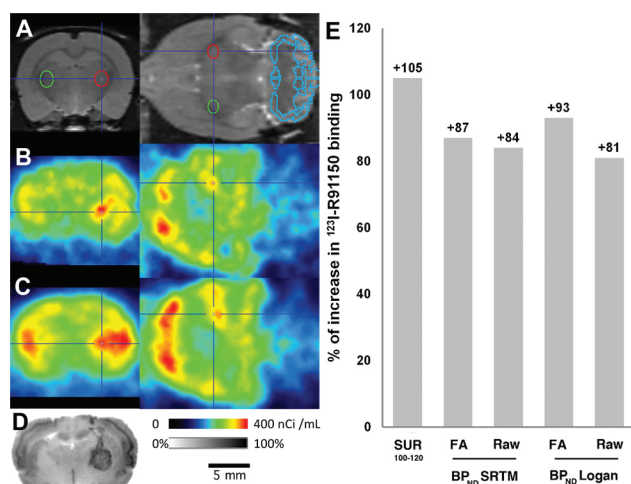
Adenoviral overexpression of 5-HT_{2A} receptors. MRI template with cerebellum and adenovirus injection-site regions of interest (ROI) (Ad5-HT_{2A}R = red ROI; Ad5-HT₄R = green ROI) (A); averaged SPECT images between 100 and 120 minutes after tracer injection in raw (B) and FA denoised data (C); autoradiogram (D); percentage of increase in receptor density estimates, measured with different methods, in the Ad5-HT_{2A}R- versus the Ad5-HT₄R-treated area (E).
